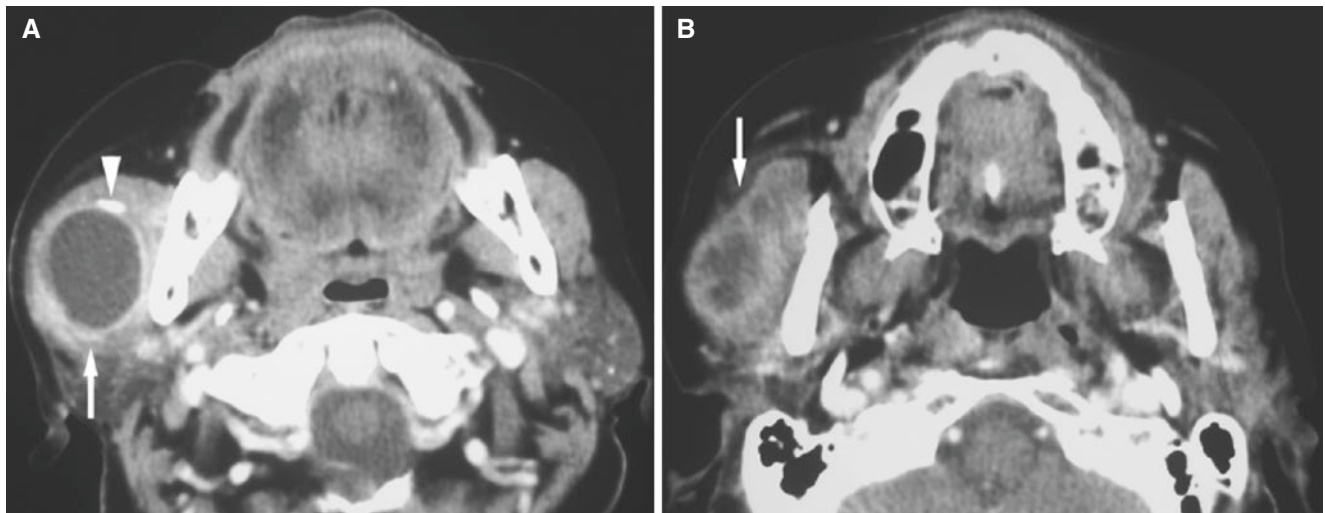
Parotid high-grade mucoepidermoid carcinoma (with evident inflammatory response); 59-year-old female with tender swelling of the right parotid gland. (A) Axial post-contrast CT image shows well-defined expansive, cystic, low-density mass with contrast-enhanced
